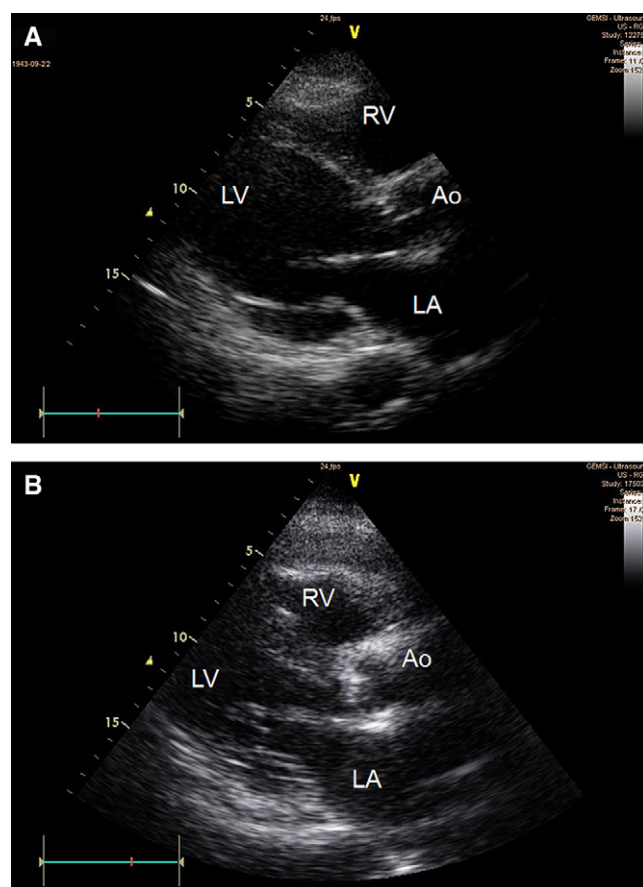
Two-dimensional echocardiographic examination, parasternal long-axis view, diastole. (A) Before thrombolysis; (B) after thrombolysis. Note decreased end-diastolic diameter of the left ventricle (LV) after thrombolysis compared with examination before the treatment. Ao, Aorta ascendens; LA, left atrium; RV, right ventricle.
